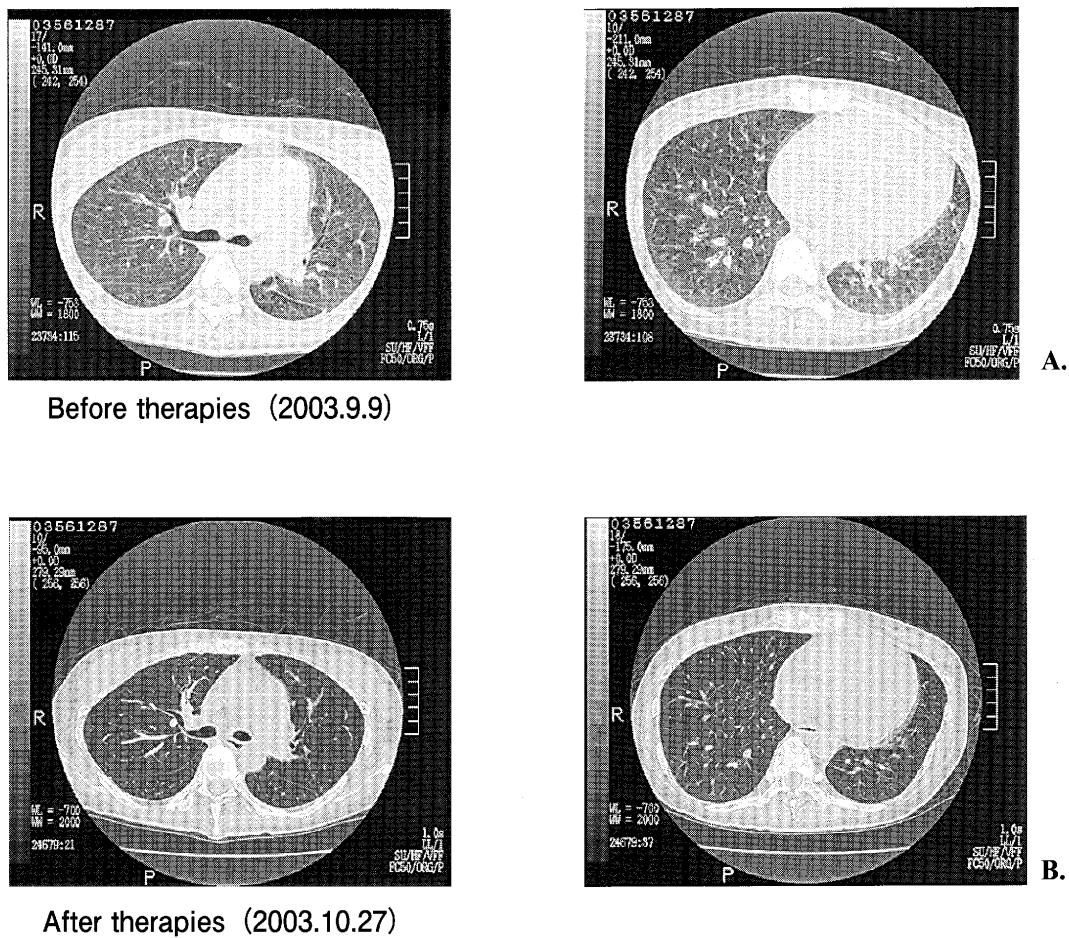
Chest CT. CT scans obtained before and after treatment. A. Upon admission, a moderate dilatation of the pulmonary trunk and right ventricle, a remarkable dilatation of the peripheral pulmonary arteries and veins, and a thickening of interlobular septa are seen. B. After treatment, the dilatation of the pulmonary trunk, right ventricle, and peripheral pulmonary arteries and veins are reduced. The right hilar lymph node swelling has decreased.
